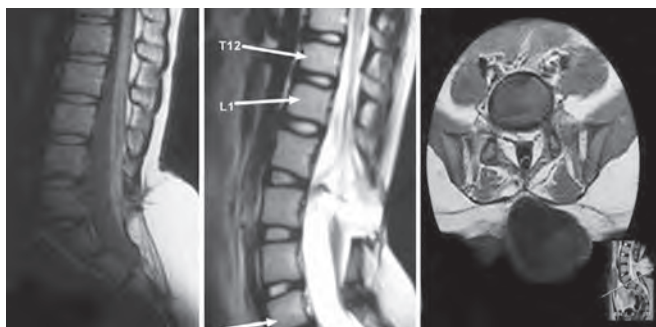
MRI of tethered cord
